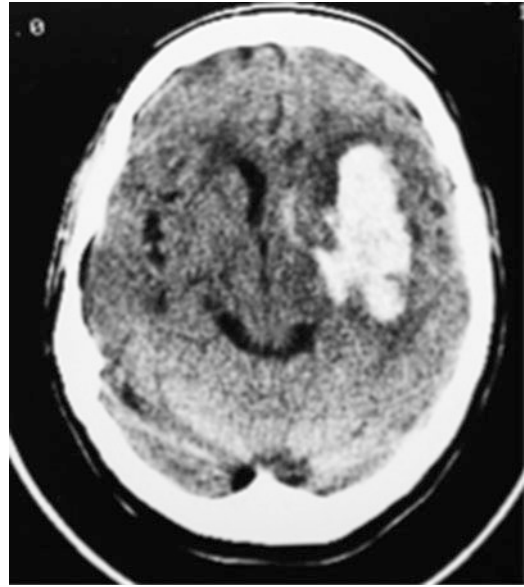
CT scan showing acute intra-cerebral haemorrhage
